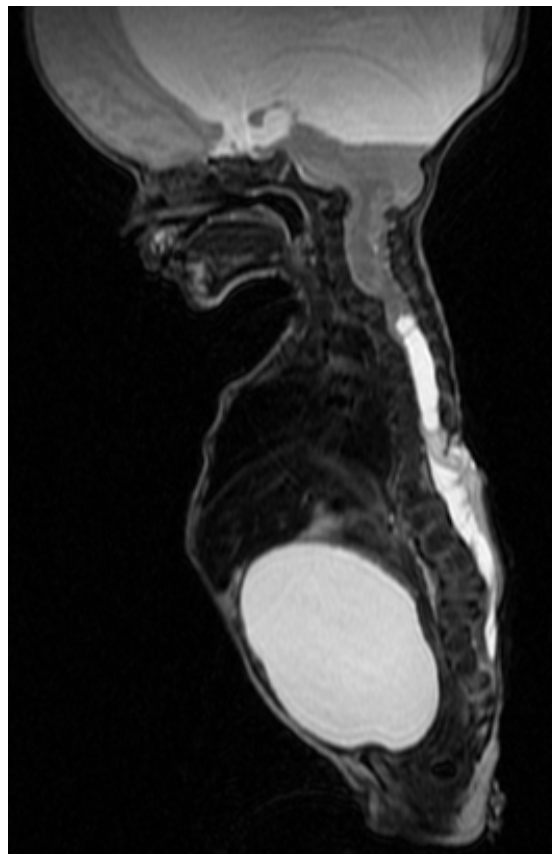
MRI section shows ectopic spine meningomyelocele.
